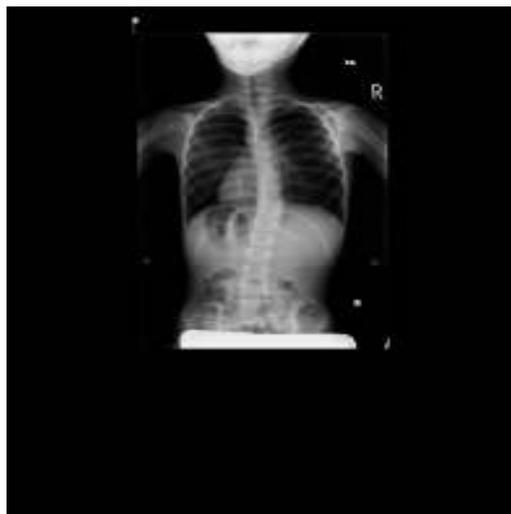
Standing A-P standing scoliosis x-ray revealed a 23 degree scoliosis, a decrease of 2 degrees since x-ray taken a year prior from 25 degrees to 23 degrees. The occiput and mandible are aligned but different than Figure 2 because 6 year molars are fully erupted and much facial bone growth has occurred.
